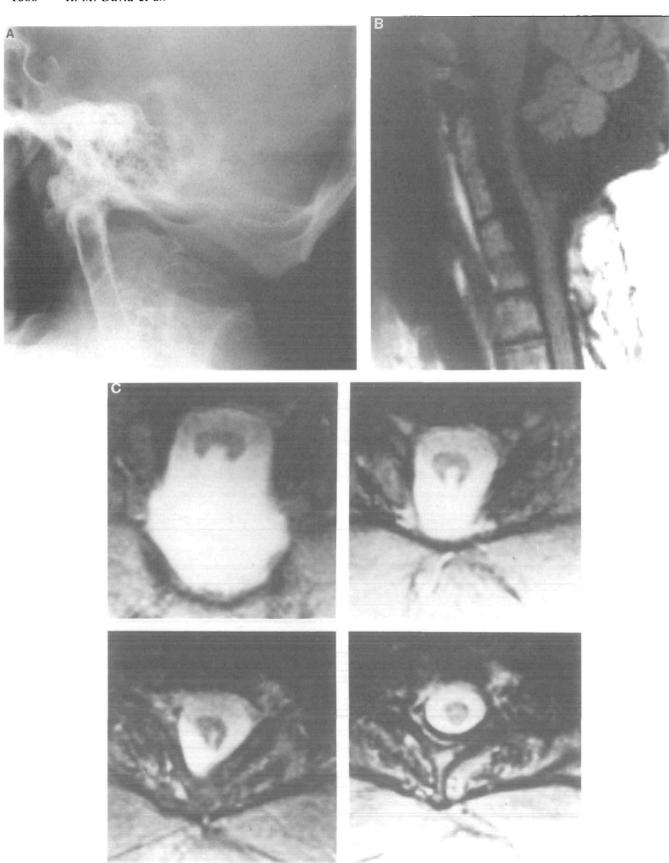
Case 6. (A) Lateral cervical roentgenogram showing extensive fusions between C2 to C6 vertebral bodies. (B) Sagittal MRI (T₁-weighted image) and (C) axial MRI (T₂-weighted image) with wide foramen magnum, absent posterior vertebral elements and partial posterior splitting of the upper cervical cord.
